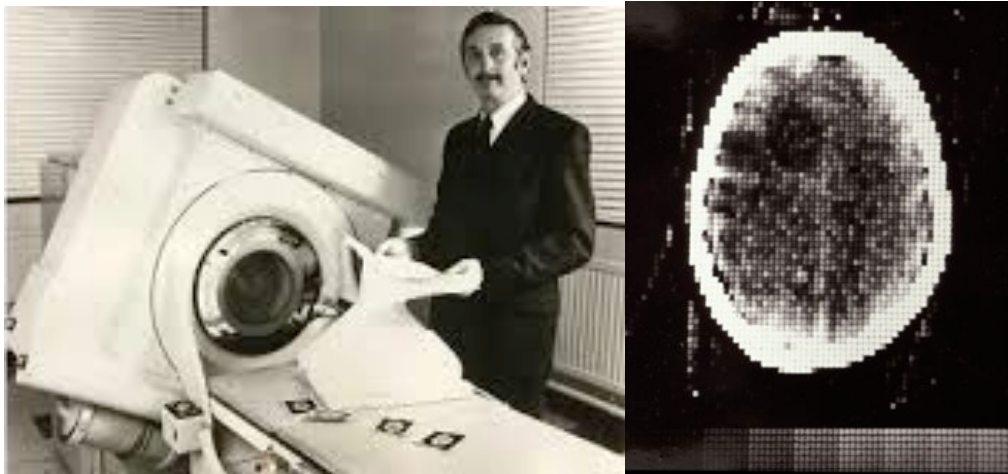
Godfrey Hounsfield beside his CT head scanner at Atkinson-Morley Hospital.
